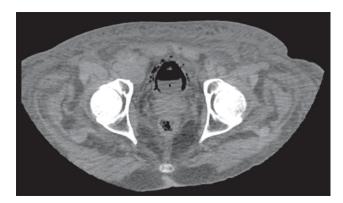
Uro-CT in axial section evidencing thickening of the bladder wall and perivesical gas.
